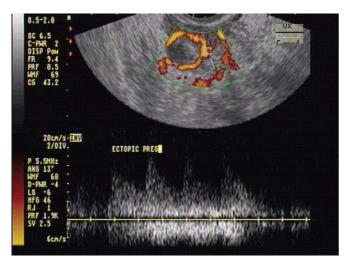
Colour Doppler findings
